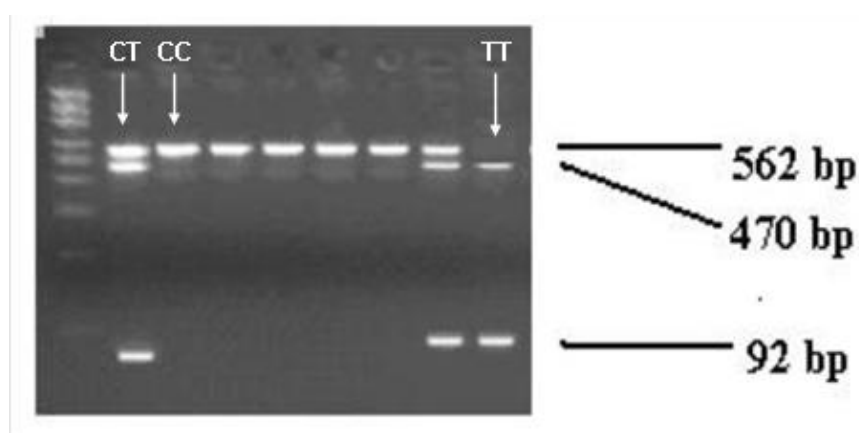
Gel electrophoresis view of samples having INS *PSTI* CC, CT and TT alleles.
